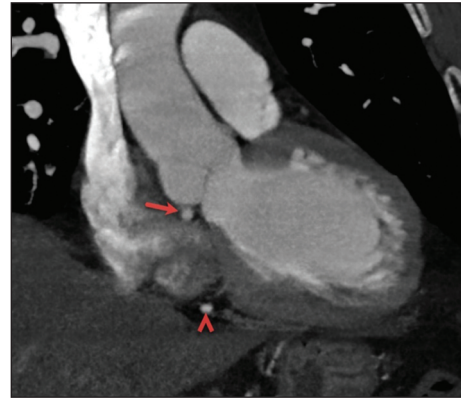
The sagittal plane image of single coronary artery on contrast-enhanced computed tomographic angiography.
